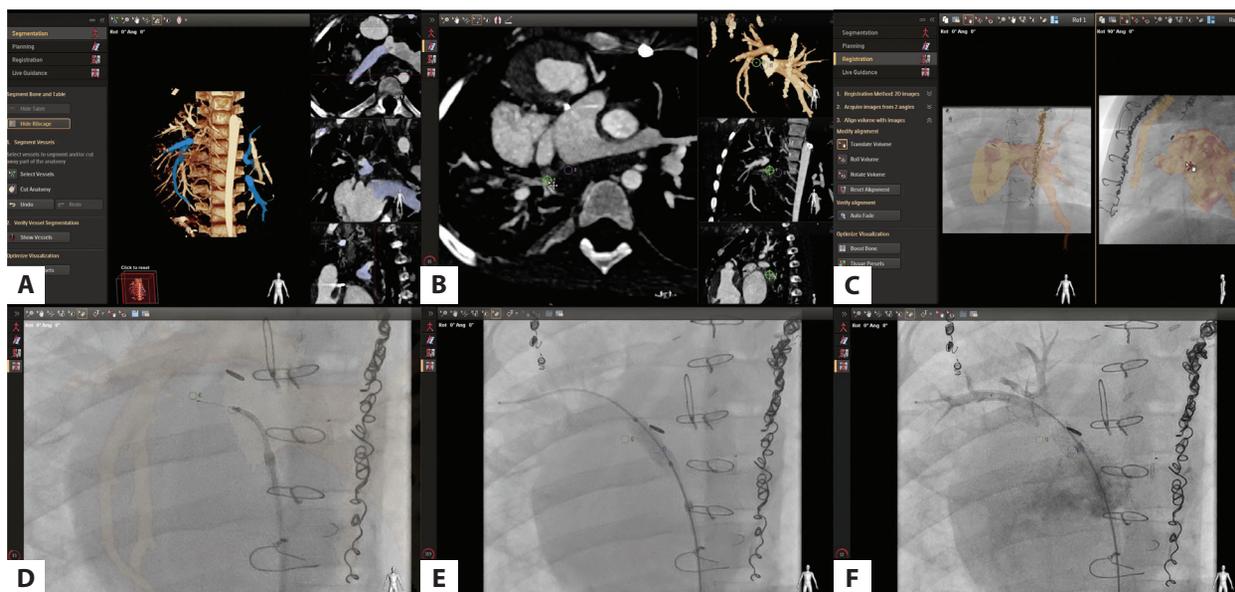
Fusion imaging for percutaneous pulmonary vein recanalization and stenting. VesselNavigator (Philips Healthcare, Eindhoven, The Netherlands) assisted the segmentation of contrast computed tomography scan (A). Pink and green marking points were placed to highlight the track between the left atrium and the right upper pulmonary vein (B). Previously placed coils were used for the registration of the 3D volume with stored fluoroscopy in two perpendicular projections (C). Three-dimensional reconstruction with marking points was used to guide pulmonary vein perforation and subsequent stent implantation (D–F)
